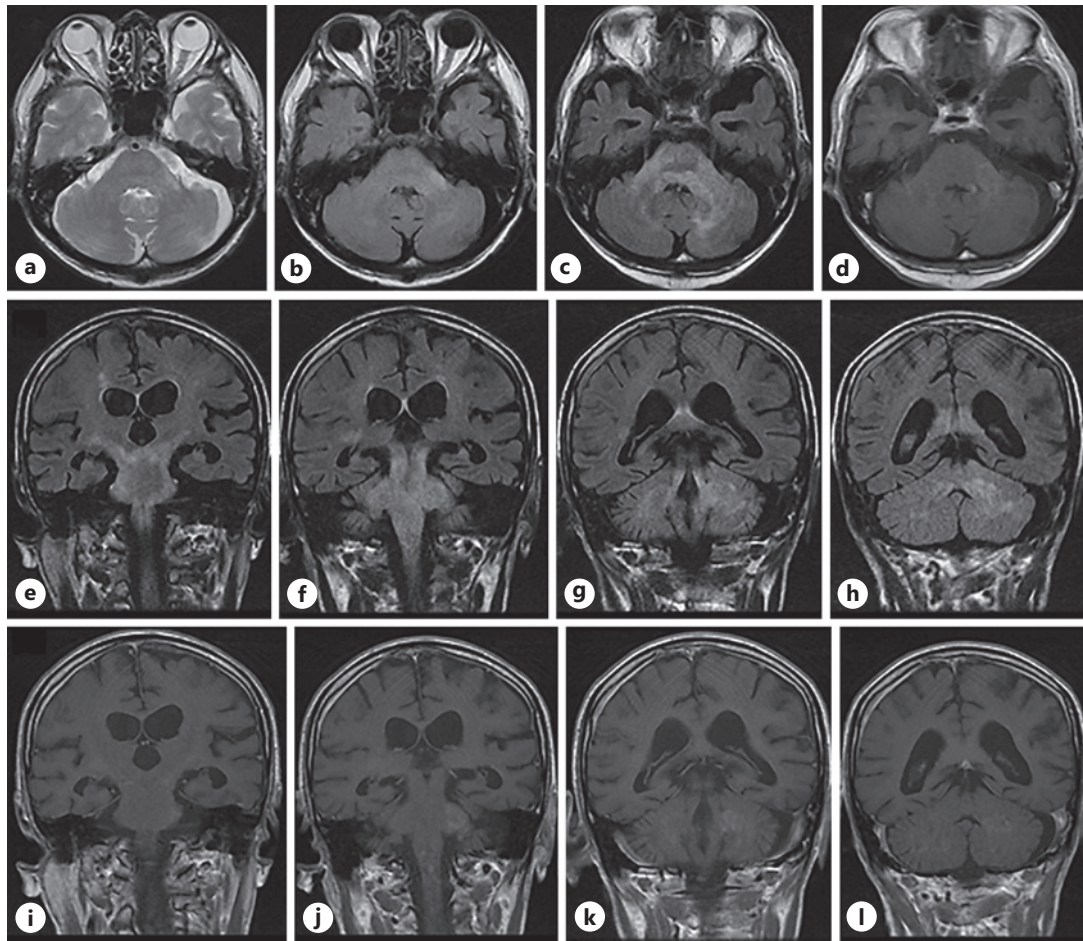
Head MRI findings. Brain FLAIR/T2-weighted imaging performed at another hospital within 1 month after symptom onset revealed high-intensity lesions in the left middle cerebellar peduncle (a, b). Brain axial FLAIR/T2-weighted imaging at the time of the patient's first visit to our hospital showed high-intensity lesions from the left middle cerebellar peduncle to the entire brainstem (c), and post-contrast T1-weighted imaging demonstrated contrast enhancement in the left middle cerebellar peduncle (d). In addition, coronal FLAIR/T2-weighted imaging showed diffuse high-intensity lesions from the pons to the midbrain, medulla oblongata, left-dominant middle cerebellar peduncle, right-dominant, posterior limb of the internal capsule, and upper cervical spinal cord (e-h), and post-contrast T1-weighted imaging showed faint enhancement effects in the left middle cerebellar peduncle and upper cervical spinal cord (i-l).
